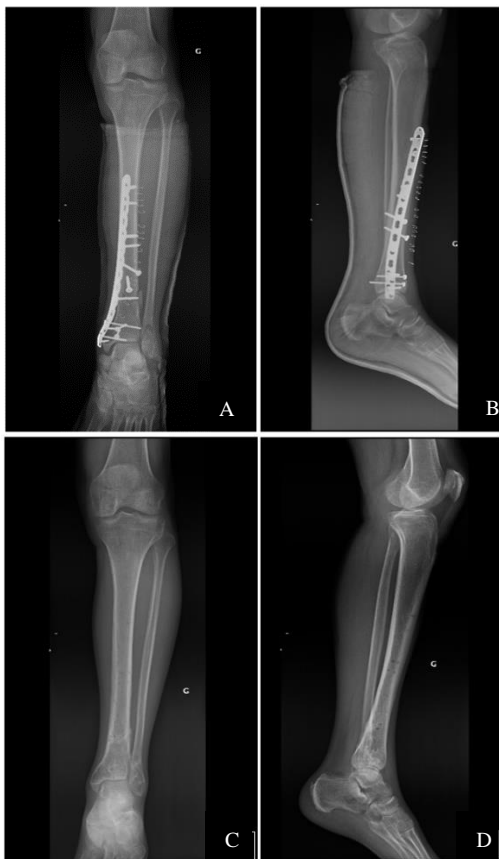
A, B) Leg X-rays at day 21 of the leg fracture with osteosynthesis material; and C, D) X-rays at 8 months after material removal.
